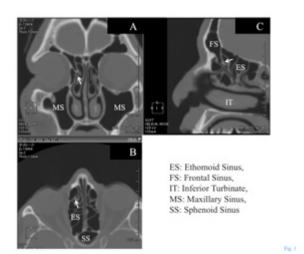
Reconstructed CT images of the paranasal cavity in a 42-year-old man without sinusitis are demonstrated. Plane A, B, and C are coronal, horizontal and parasagittal planes, respectively. Arrows demonstrate the narrowest point of the frontal recess in each plane.
